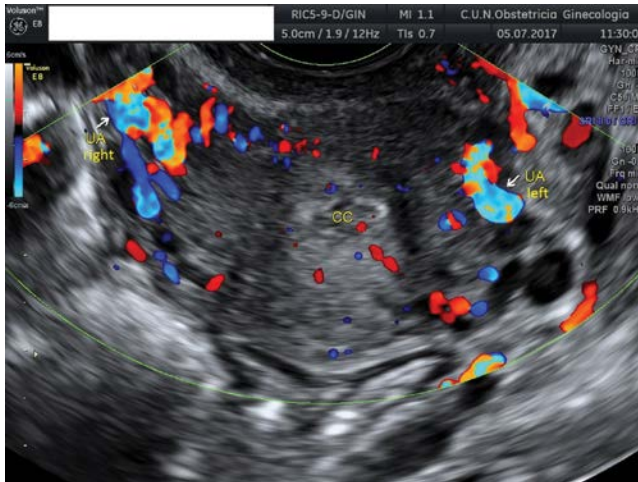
Transvaginal ultrasound showing both uterine arteries (UAs) at both sides of the cervix. The cervical canal (CC) can be observed.
